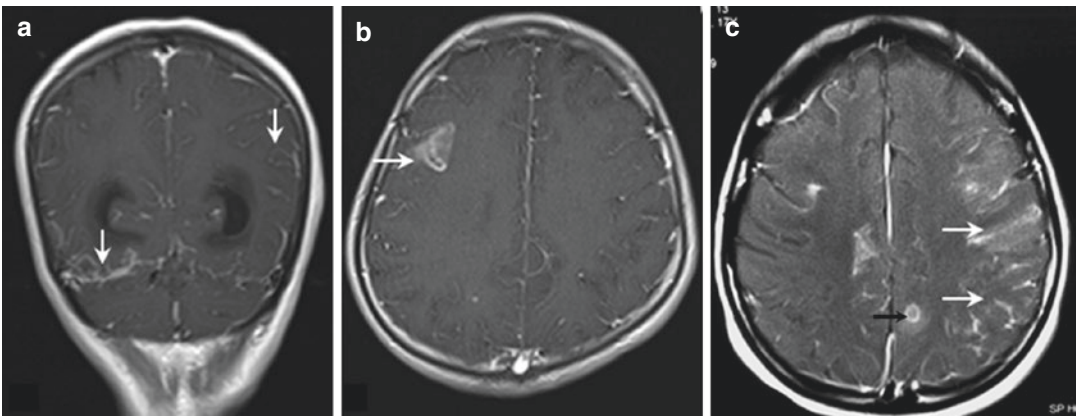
Meningeal TB. Coronal (a) and axial (b, c) post-contrast T1-weighted MRIs show leptomeningeal enhancement (white arrows). A small tuberculoma in left parasagittal parietal region (black arrow in c) is also evident
